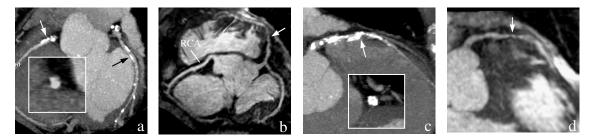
CTA (a, c) and MRA (b, d) images from a patient with calcified coronary arteries. a): CTA showed multiple calcification nodus in the proximal RCA (white arrow) and LCX (black arrow), it was difficult to evaluate the luminal narrowing in the proximal RCA on the cross sectional multiple planner reformat image (white box); b): Reformatted whole-heart CMRA demonstrated no significant stenosis at the calcified site in RCA and LCX but a significant stenosis (>50%) caused by the diffuse calcification in the proximal LAD (arrow); c): CTA demonstrated diffuse calcification in the proximal LAD (arrow). It neither depicted the coronary lumen nor assessed the stenosis on the cross sectional MPR image (white box) due to the overlapping and blooming artifact of calcification; d): Maximum intensity projection image of whole-heart CMRA demonstrated the irregular lumen with a significant stenosis in the proximal LAD (arrow).
